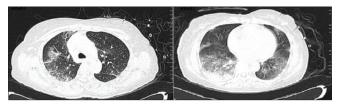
High-resolution computed tomography chest showing multiple areas of crazy paving and dense consolidation in the right lower lobe
